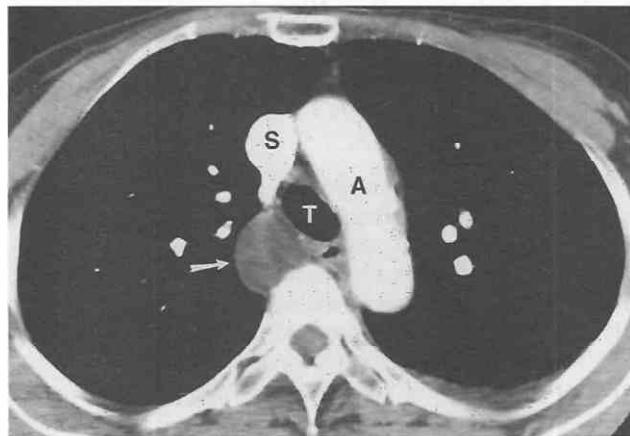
Bronchogenic cyst. Contrast-enhanced CT shows well-circumscribed, water-attenuation middle mediastinal mass (arrow) with imperceptible wall. The CT appearance is typical for bronchogenic cyst. A, transverse aorta; S, superior vena cava; T, trachea.
